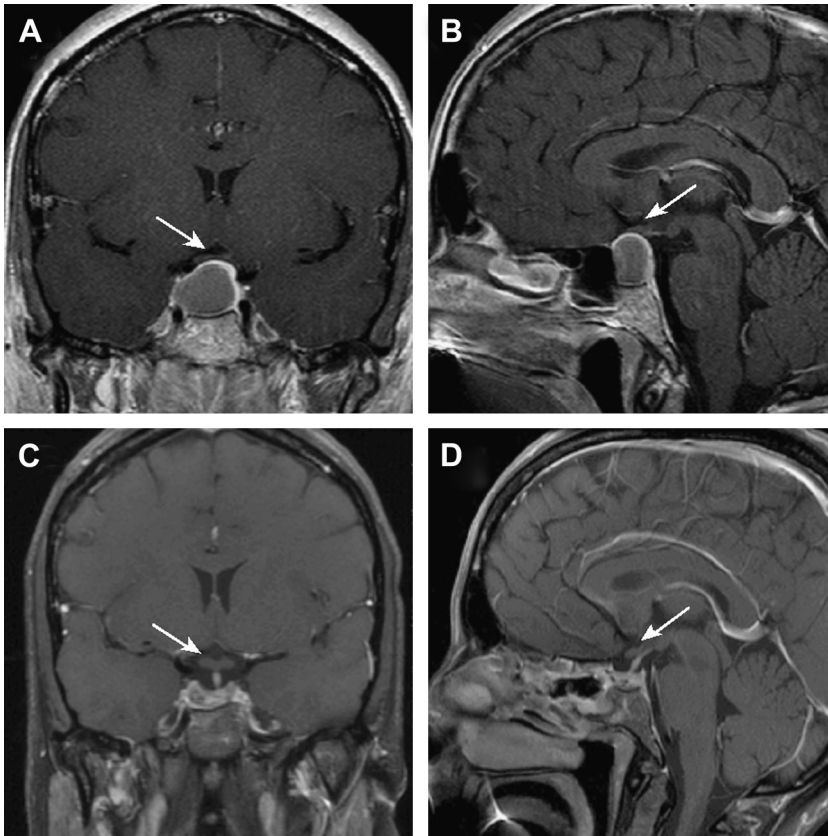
A 38-year-old woman presenting with amenorrhea. Laboratory workup revealed elevated prolactin at 85 ng/mL, suggesting that the tumor was a cystic microprolactinoma rather than a cystic nonfunctioning pituitary adenoma with stalk effect. Gadolinium-enhanced T1-weighted images (A, B) confirmed a cystic lesion with suprasellar extension and compression of the optic chiasm (arrows). Although with bromocriptine her prolactin level normalized to 14.1 ng/mL, the tumor size did not respond to medical treatment. Normalization of serum prolactin to medical treatment suggested that this lesion is indeed a prolactinoma. She underwent transsphenoidal resection of the tumor with decompression of the cystic component (C, D), which resulted in decompression of the optic chiasm (arrows). Surgical pathology confirmed the lesion as prolactinoma.
